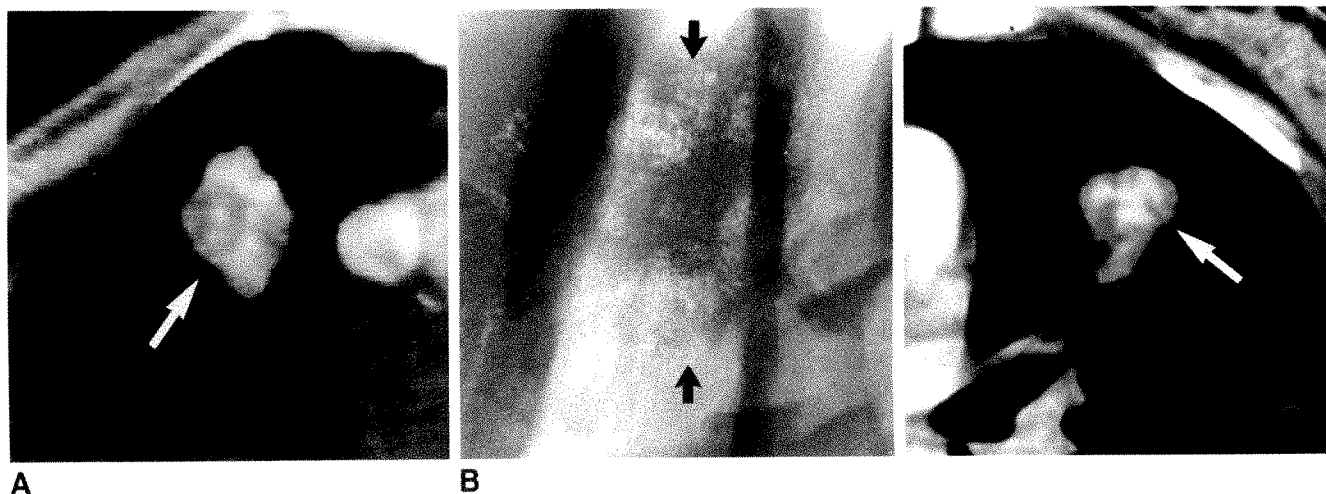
A, CT scan of 47-year-old woman shows multiple foci of high density throughout a lobulated right upper lobe mass (arrow). Although a contrast drip infusion was used, intensity of these foci (maximum CT number: 240 H) was thought to be far in excess of that which might be produced by contrast enhancement with this technique.
